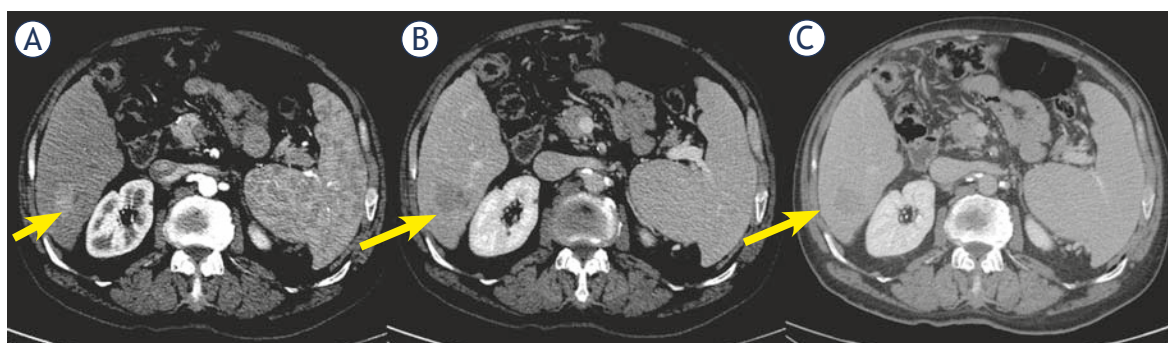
Woman 68 y with combined hepatocellular-cholangiocarcinoma (cHCC-CCA) on VI hepatic segment. Multidetector computed tomography (MDCT) study. The nodule shows hypervascular appearance (arrow) during arterial phase of contrast study (A), with wash-out appearance (arrow) and without capsule appearance (arrow) during portal and late phase of contrast study (B and C).
